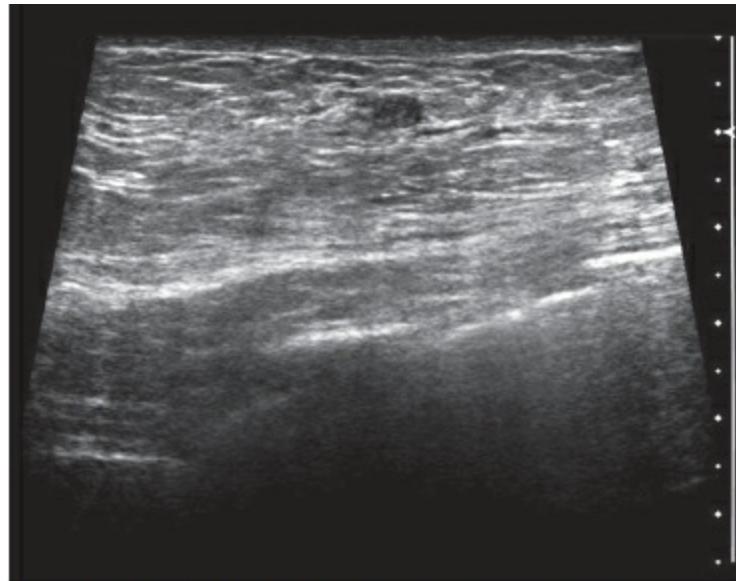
IMAGE QUALITY: FOV. The lower portion of this trapezoidal image contains no information. Small, 0.4×0.3 cm, mass located 0.8 cm deep from the skin is poorly visualized in this sonogram set to a depth of 5.5 cm. Image appears minified.
